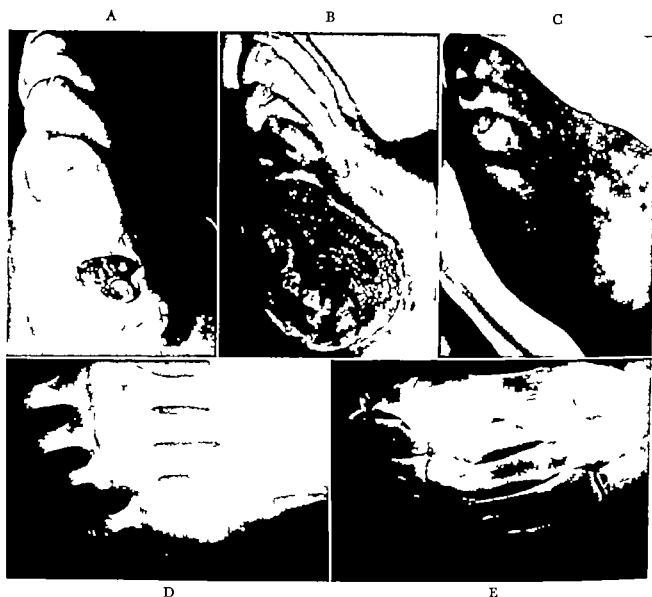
(A) Diabetic gangrene with draining sinus leading to fragmented bone. (B) Granulation tissue after chemosurgical amputation. (C) Healed lesion. (D) Roentgenogram showing destruction of bone around the metatarsophalangeal joint. (E) Appearance of bone after chemosurgical amputation.
